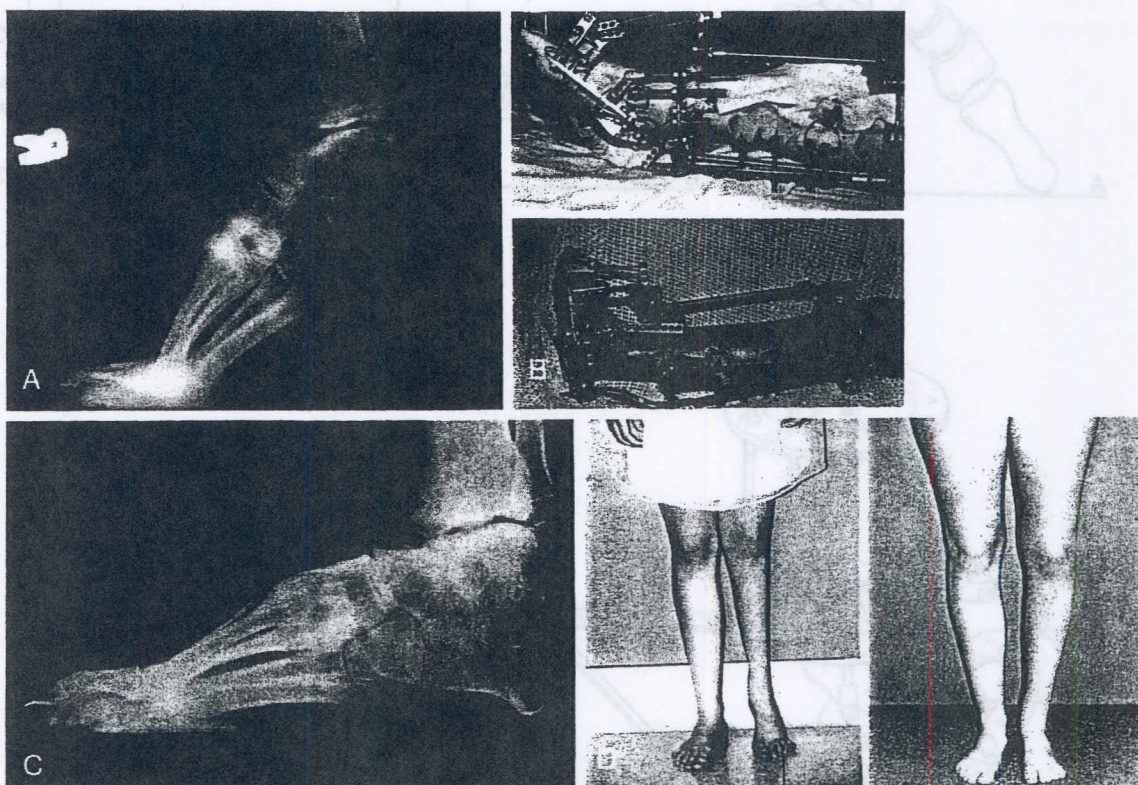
(A), A 15-year-old girl with postclubfoot flat-top talus and 8 cm of discrepancy. There is a subtalar congenital coalition. (B), The apparatus at the onset of treatment (top) and at the end of the deformity correction (bottom). This leg was also lengthened and widened. (C), The final radiograph demonstrates a plantigrade foot with restoration of foot height through the U-osteotomy. The correction was performed gradually. (D), At the onset of treatment (left), note the extremely thin calf and the fixed equinus deformity. At the end of treatment (right), note the widening and reshaping of the calf. The foot is now plantigrade. (Courtesy of Dror Paley, M.D.)
